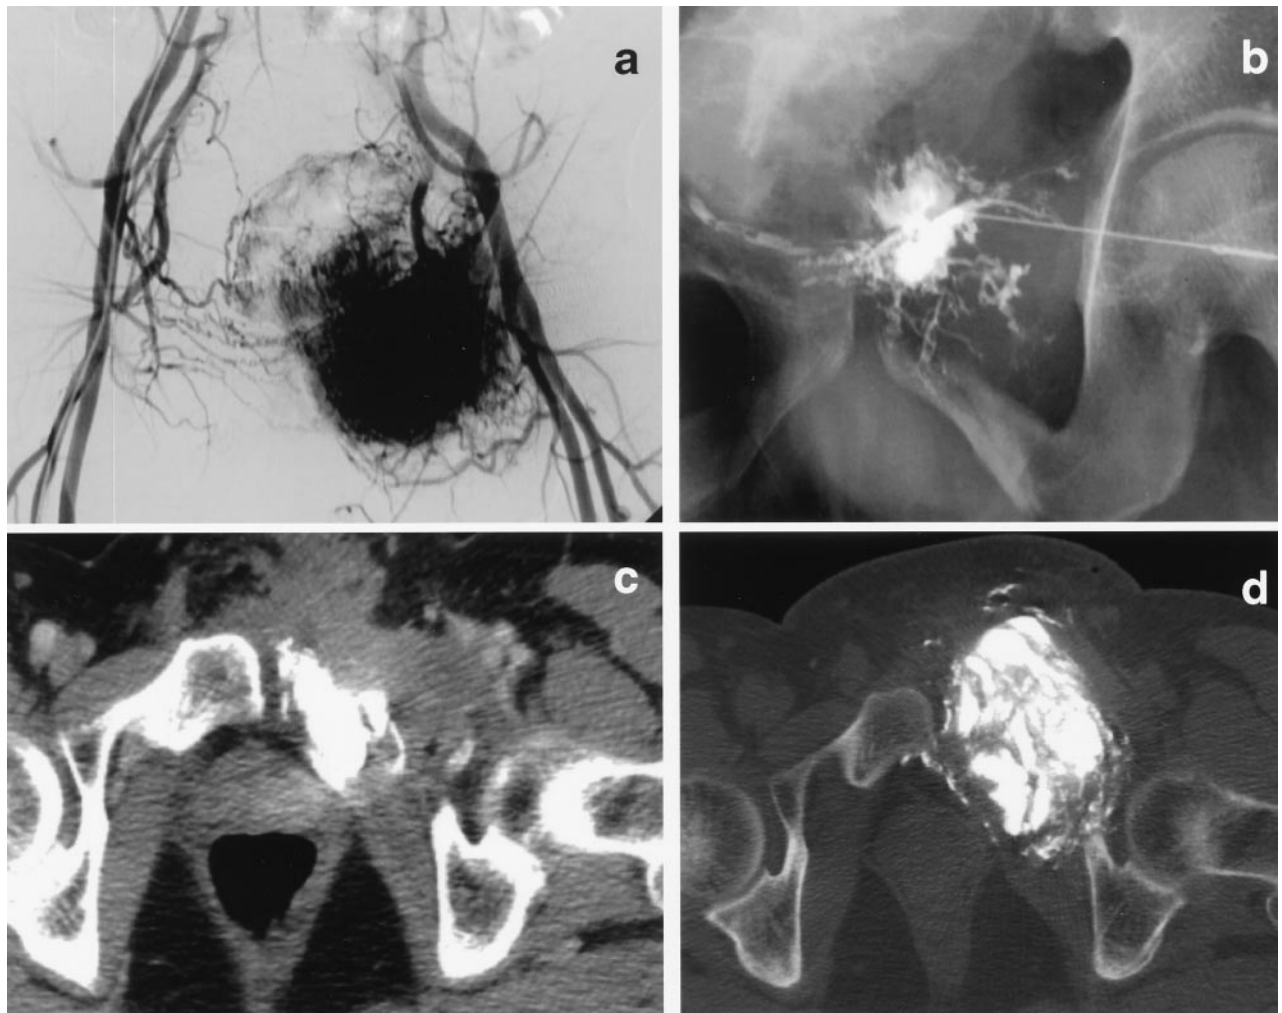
(a) Global angiography of pelvic region revealing the highly vascular tumor with extensive arterial tumor blush. (b) Direct access to the tumor parenchyma and associated draining veins by percutaneous puncture with a 20-G needle allowing for contrast material injection and subsequent plastification of the tumor accordingly. (c) Posttreatment CT after incomplete surgical removal with residual tumor area opacified by NBCA implant. (d) Follow-up CT 1 year later shows local recurrence adjacent to the plastified tumor area.
